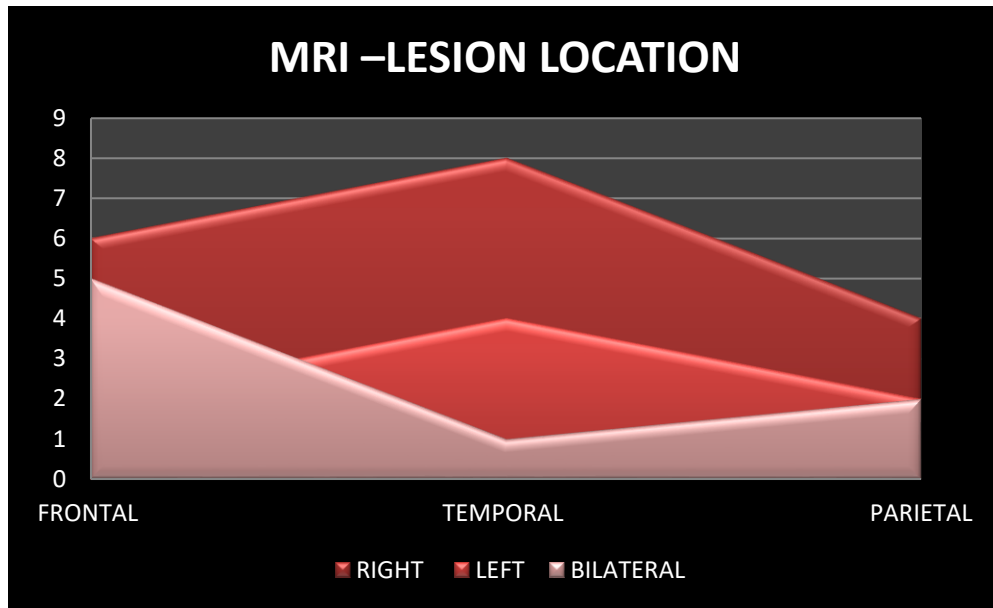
MRI-Lession Location
